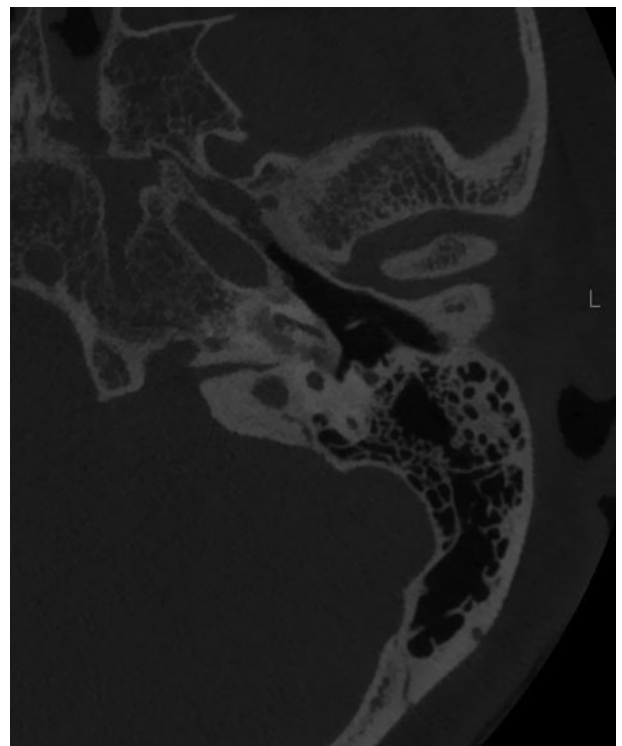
High-resolution cone-beam computed tomography of left petrous temporal bone demonstrating abnormally narrowed basal turn of cochlea.
